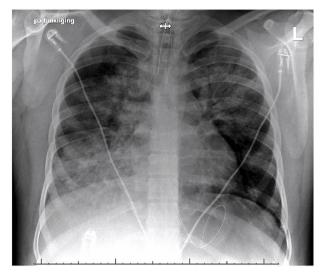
X-ray imaging of the chest in supine position after transfer to our hospital on second day of admission, showing bilateral patchy opacities.
